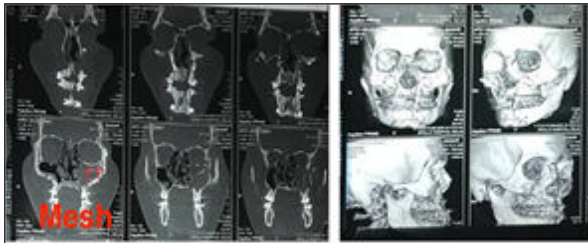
CT Scan 3D Face shows comminuted fracture of walls of maxillary sinuses. Metallic mesh in floor of left orbit. Multiple metallic fixator seen over maxillary sinus wall
